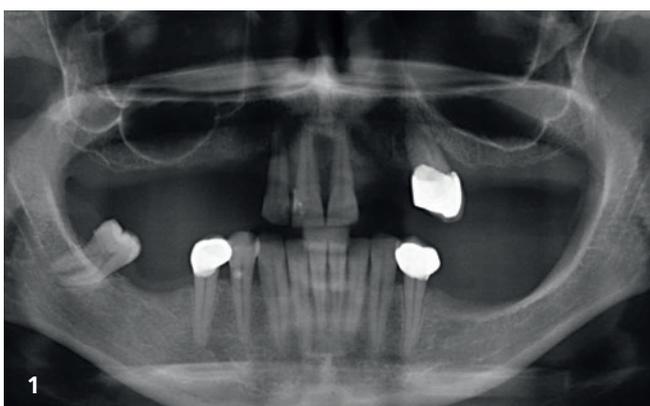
Initial condition of the patient in 1998, showing the edentulous sections to be rehabilitated with implants and the bone loss of the teeth in the upper arch, as well as the lateral focus of the premolar in position 24. Fig. 2: X-ray one year after treatment where we can see the rehabilitation carried out with implants and the periodontal maintenance of teeth 11 and 21, which is giving good results. At this point, the patient decides not to rehabilitate the lower arch.
